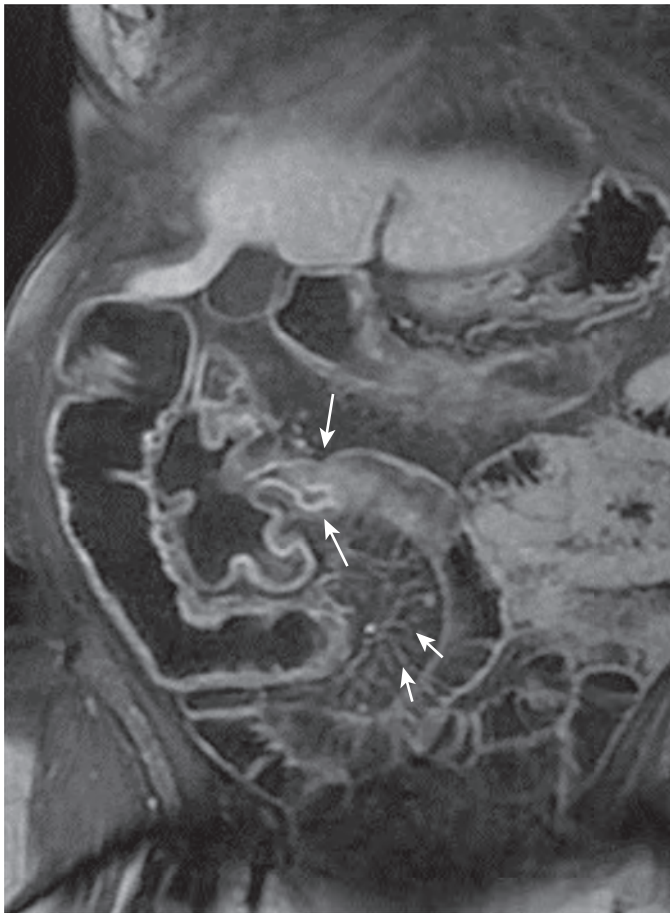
MR enterography in 36-year-old man with suspected Crohn's disease. Coronal contrast-enhanced T1-weighted fat-saturated VIBE image of terminal ileum shows uniform wall enhancement of terminal ileum with normal thickness (*long arrows*), a finding that indicates mild inflammatory changes. Note increased vascularity in the adjacent small bowel mesentery (*short arrows*).
